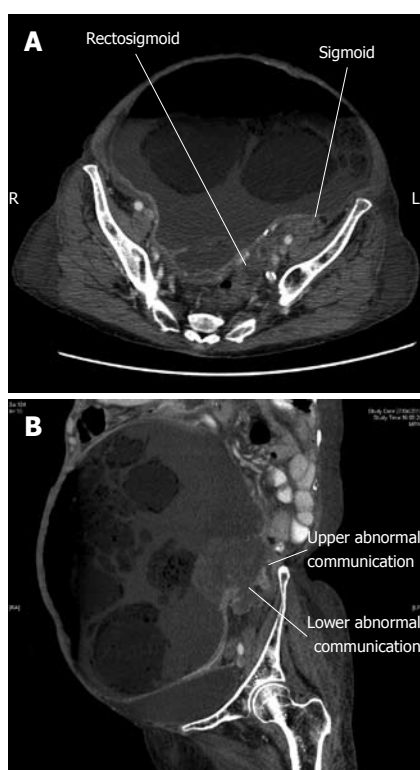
Computed tomography scan. A: Cross-sectional view; B: Sagittal view.
